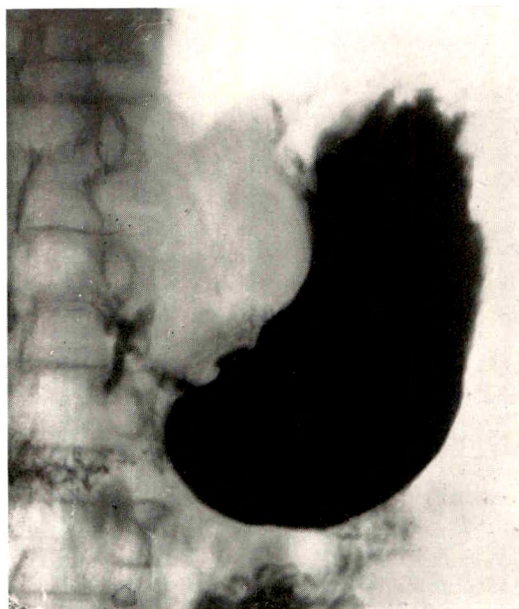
The roentgen diagnosis was duodenal and gastric ulcer. The position of the gastric ulcer niche was recorded by the roentgenologist as being "at the upper margin of the deformed prepyloric area," but the pathologist placed the lesion within one inch of the pyloric valve.
